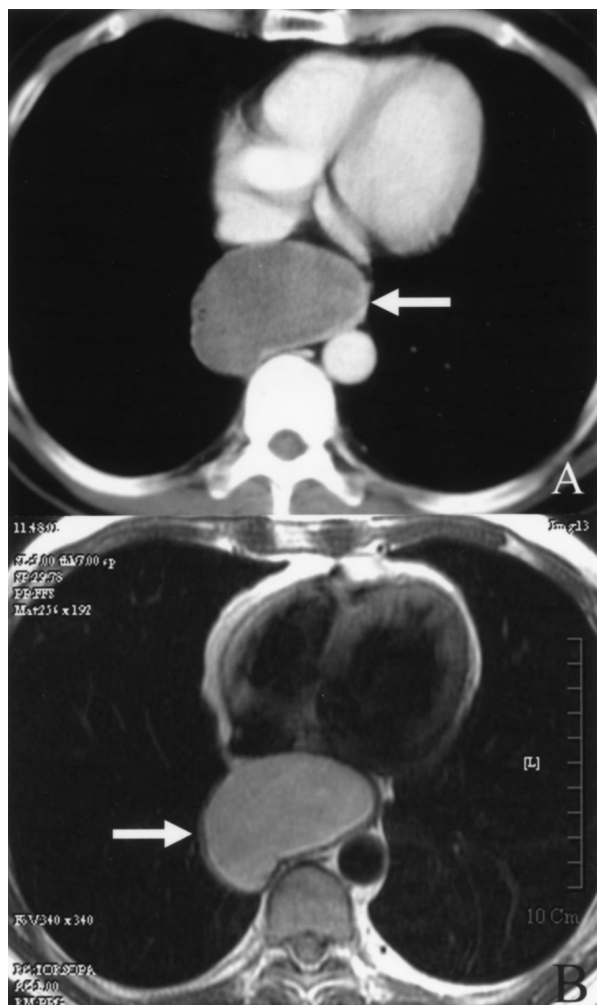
CT (A) and MRI scan (B) of patient 2 reveals a hypodensed, homogenous lesion with mild ring enhancement (arrows). The esophageal structure was deformed at this level due to severe external compression.
